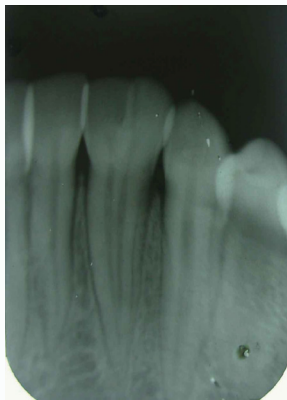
Intraoral periapical radiograph showing complete fusion of central and lateral incisors.
